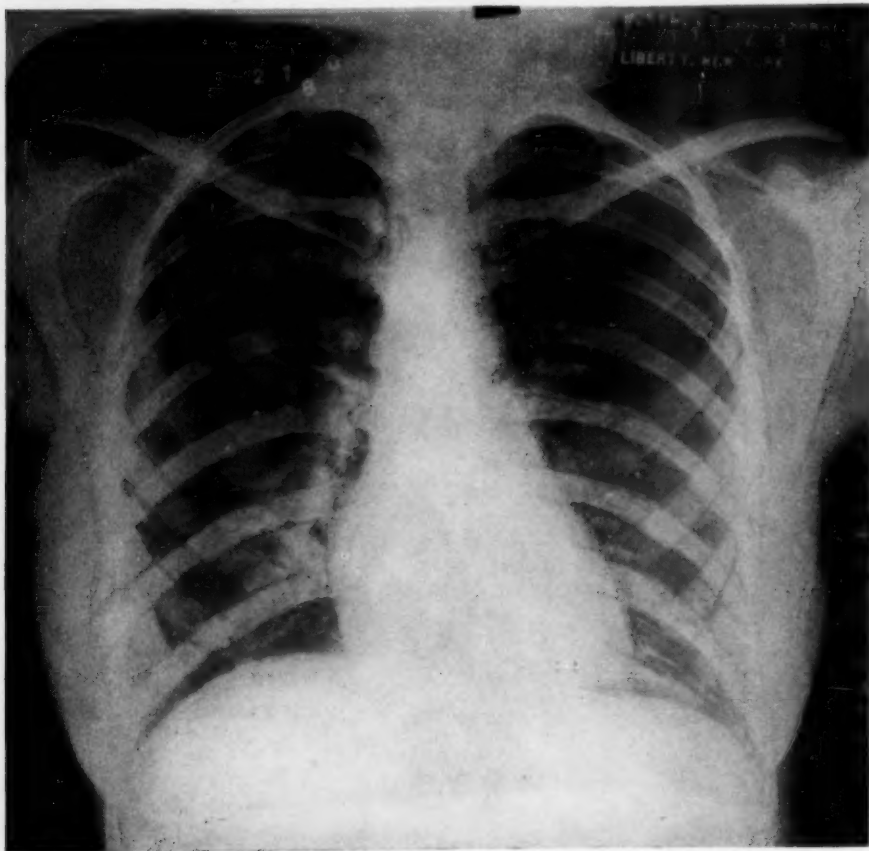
(Case 2.) Roentgenogram taken November 13, 1937. Marked clearing of the right lung field.
